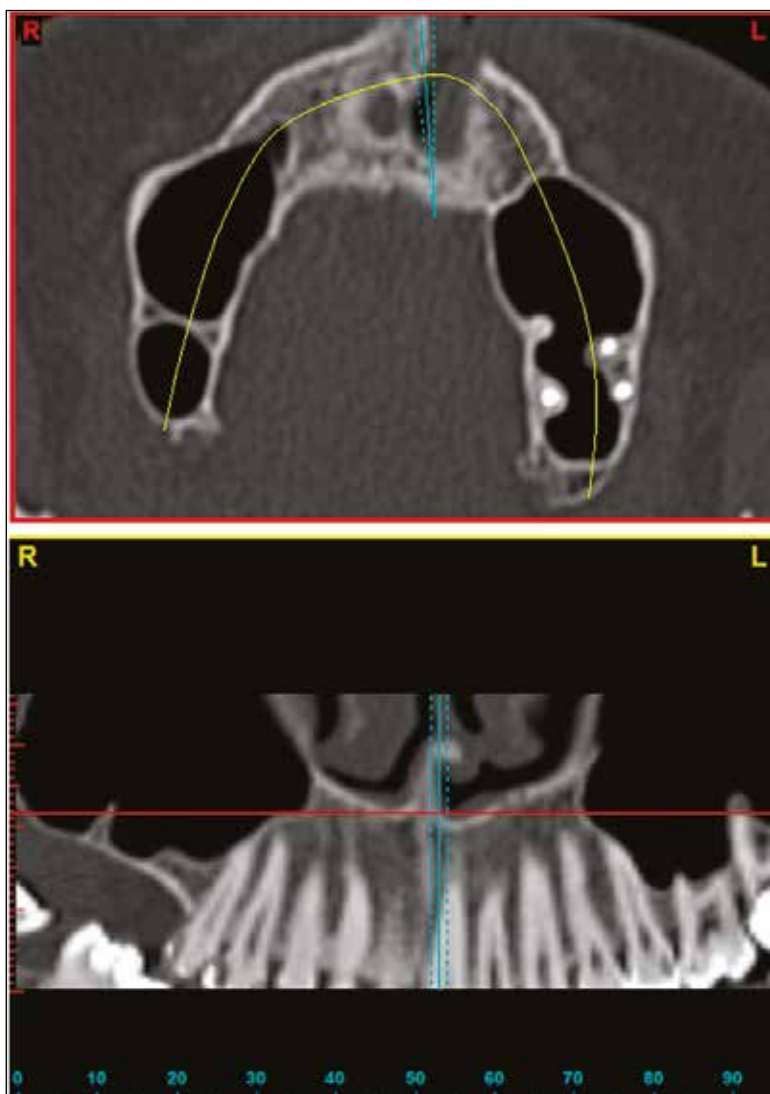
Fragment of computed tomography of the upper jaw of the 49-year-old male patient G., case record No.105. Bone septum is presented in the right maxillary sinus.
